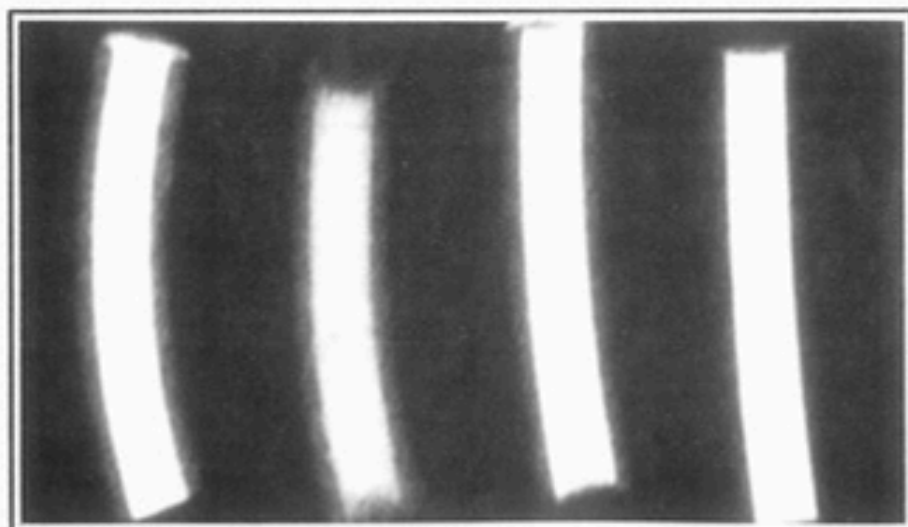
Radiographic evaluation
